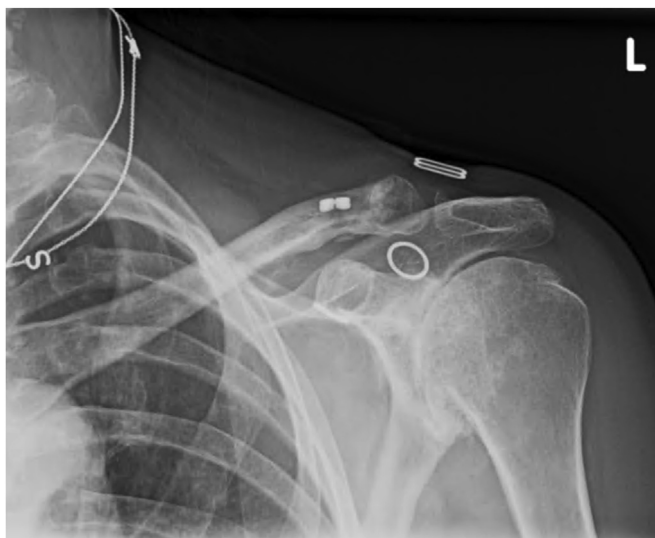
Postoperative anteroposterior and Zanca view radiographs following distal clavicle fixation with coracoclavicular ligament stabilization.
